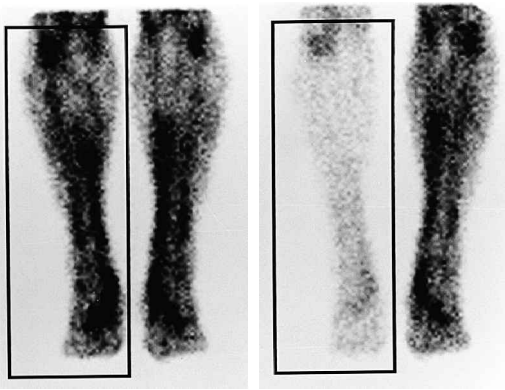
An example of a 1-minute scintigram of the lower limbs of a 25-year-old man obtained by ^{99m}Tc -radiolabeled erythrocytes showing the limbs from an anterior projection before and after an Esmarch exsanguination of the right limb. The frame represents the region of interest. The percentage reduction in blood volume, calculated from counts obtained before and after the exsanguination, was 61% here.
